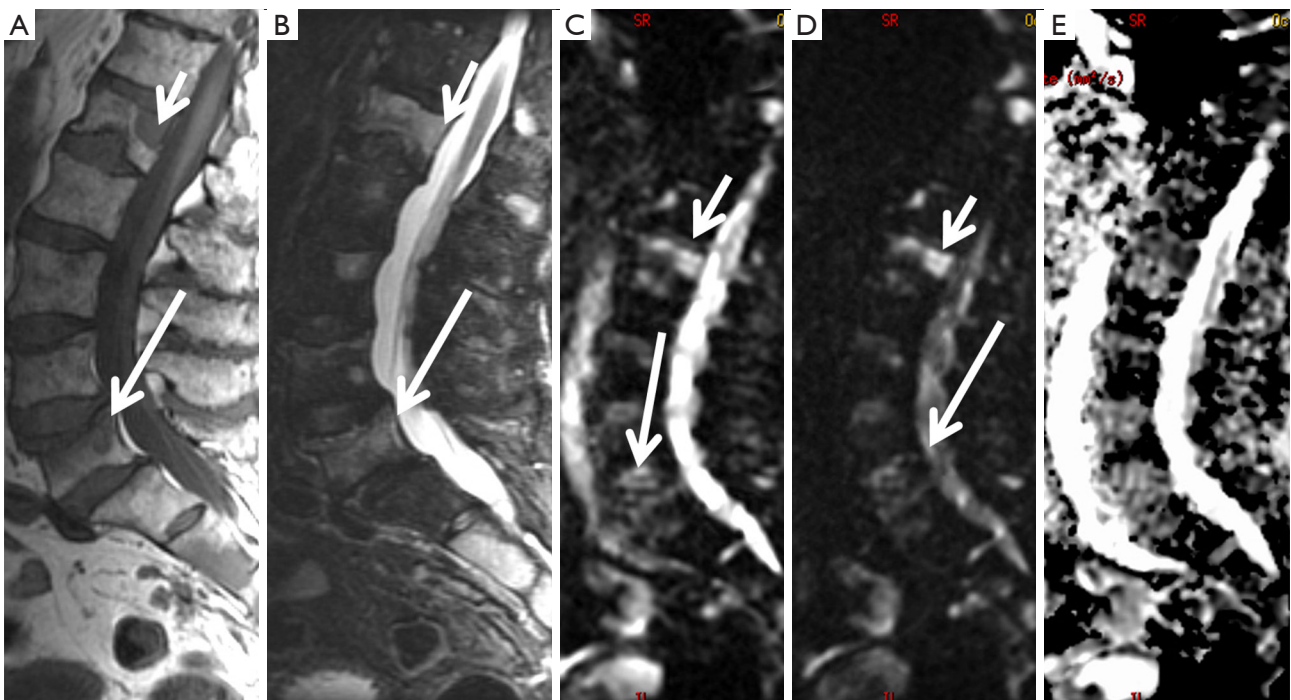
Benign and malignant edema on the ADC map. Lumbar MRI in a patient with known bone metastasis from breast cancer, currently presenting with acute low back pain. (A) Sagittal in FSE T1 showing multiple focal lesions, especially in L1 (short arrow) and diffuse edema in L5 (long arrow). (B) The corresponding sagittal STIR shows a more diffuse edema at both levels that is difficult to differentiate whether infiltrative or non-infiltrative. (C) Sagittal diffusion at $b=0 \text{ mm}^2/\text{s}$ and (D) at $b=800 \text{ mm}^2/\text{s}$ showing the persistence of hypersignal from the lesion at the level of L1 (short arrow) and lower signal at L5 (long arrow). (E) The sagittal section on the ADC map confirms the hypointensity in L1 (short arrow) with an ADC value of $0.7 \times 10^{-3} \text{ mm}^2/\text{s}$ and hypersignal in L5 with an ADC value of $1.6 \times 10^{-3} \text{ mm}^2/\text{s}$. The lesion in L1 is due to a metastasis and in L5 due to an insufficiency fracture, where the sagittal FSE T1 image (A) shows a subcortical horizontal line (arrow), which justifies the current symptoms. ADC, apparent diffusion coefficient; MRI, magnetic resonance imaging; FSE, fast spin echo; STIR, short tau inversion recovery.
